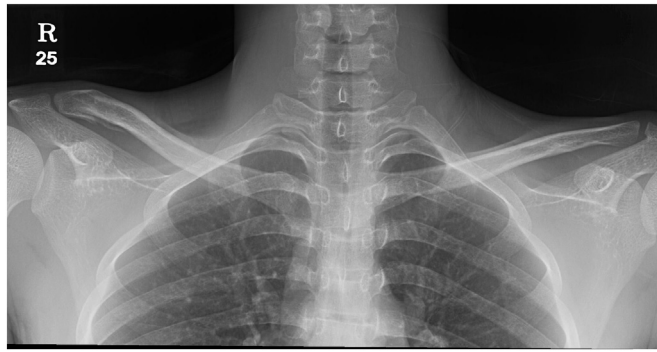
Anteroposterior radiograph of the both clavicle after removal of TEN.
